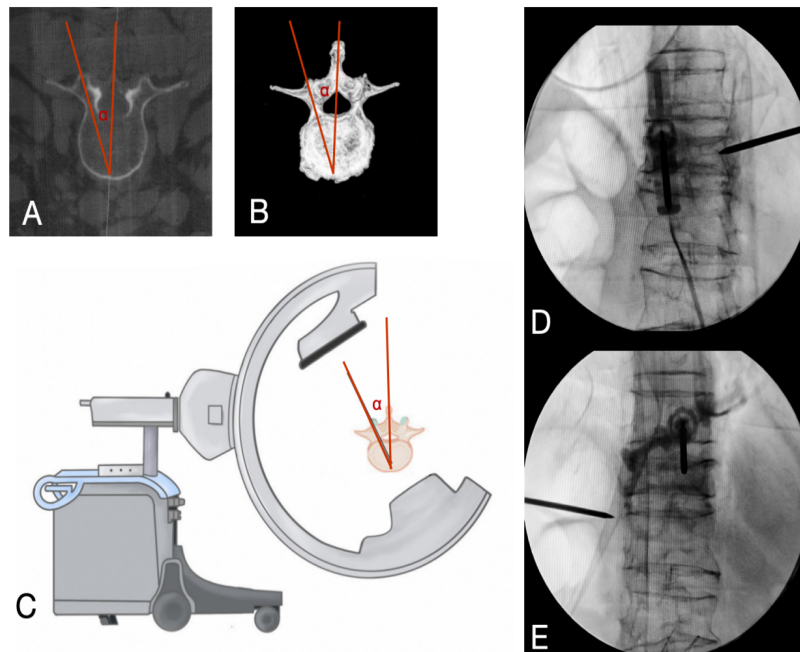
A, B) Measurement of the angle α of the midline of the spinous process adjacent to the axial position of the pedicle in three-dimensional CT scan. C) Flipping the c-arm x-ray machine to angle α to obtain axial images of the pedicles. D, E) Showing the puncture needle pointing towards the centre of the circular projection of the pedicle in the axial view of the pedicles.
